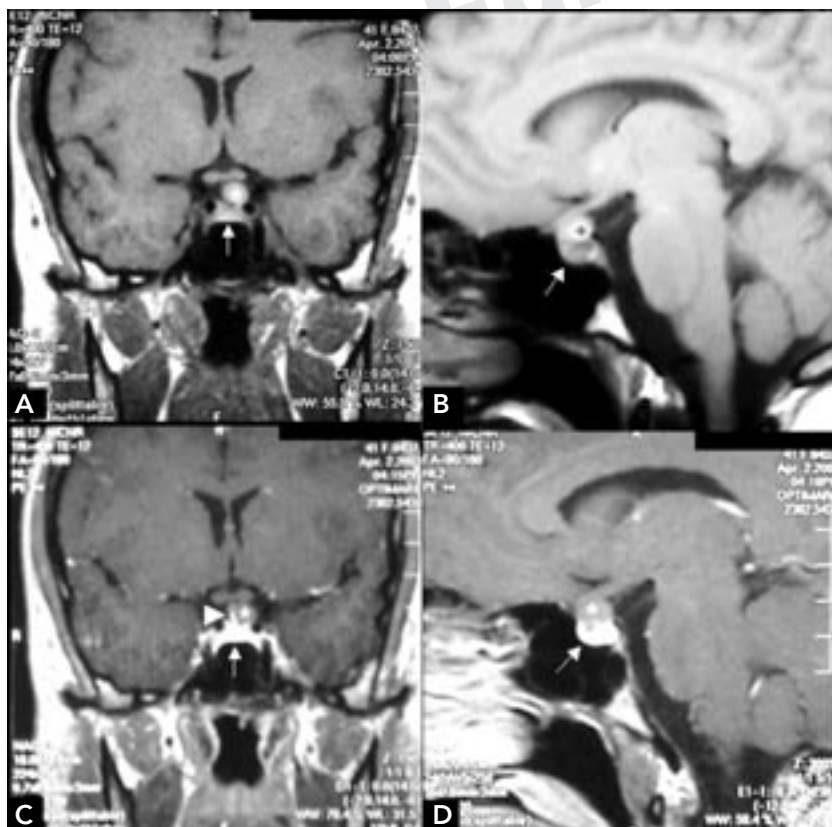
Sellar magnetic resonance imaging (MRI) of a suprasellar Rathke's cleft cyst (RCC) before (A, B) and after (C, D) iv administration of gadolinium-DTPA. Coronal (A, C) and sagittal (B, D) images. The cyst (\*) appears as a homogeneous isointense lesion sitting atop the pituitary gland (arrow) and displacing the pituitary stalk to the right (arrowhead). The cyst does not enhance with gadolinium.
